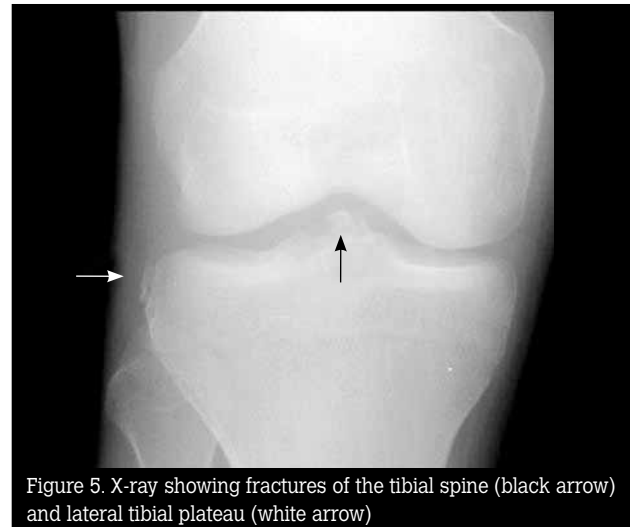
X-ray showing fractures of the tibial spine (black arrow) and lateral tibial plateau (white arrow)
